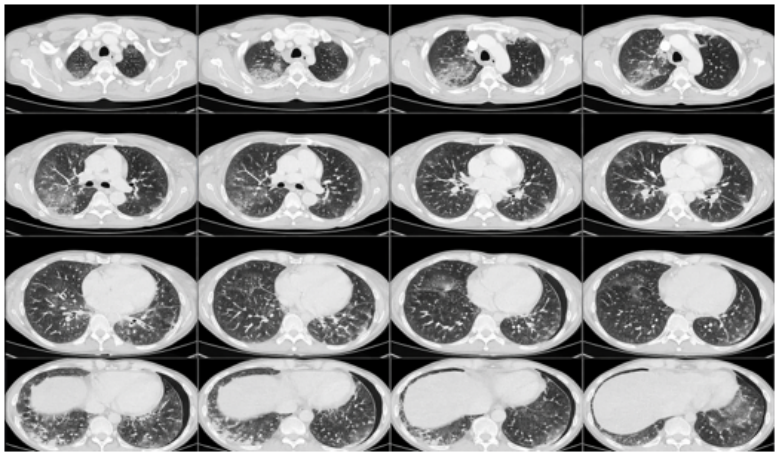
Initial chest CT (lung window): bilateral ground-glass opacities predominating in the upper lobes and right postero-basal region - the first aspiration lesions.
